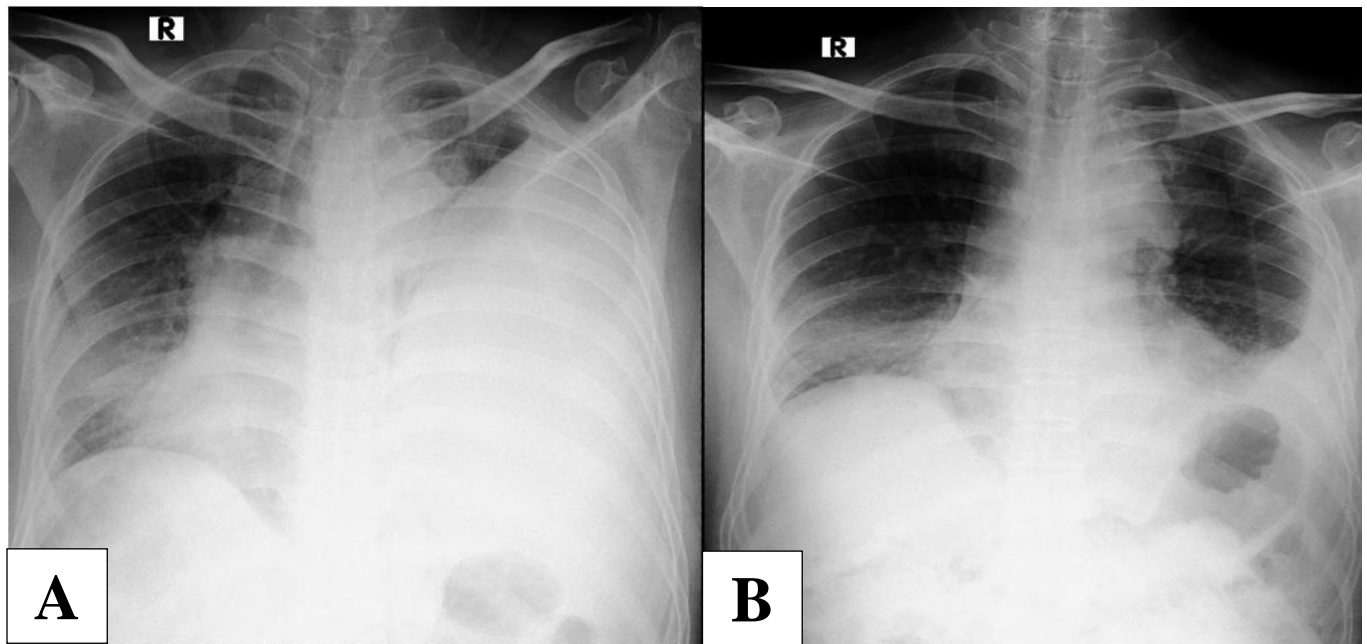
(A) Chest X-ray revealed a pneumonia infection on basal of dextra lung and pleural effusion of left hemithorax; (B-C) Chest X-ray revealed a decreased left pleural effusion and collapsed left lung with a pleural visceral line; (D) Chest X-ray on day 7 of hospitalization revealed decreased pleural effusion but not in lung re-expansion.
